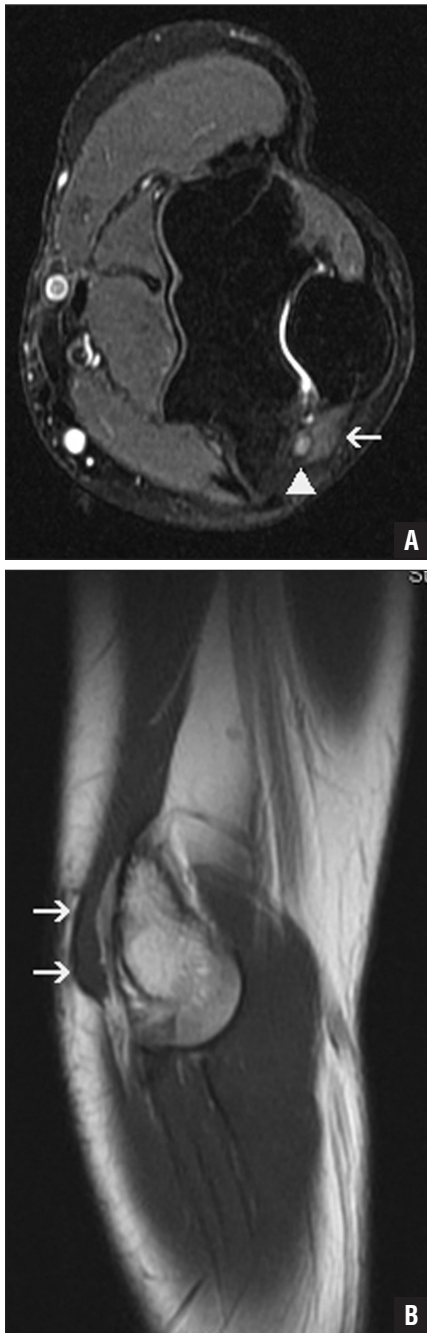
Axial T2-weighted fat-saturated (A) and sagittal T1-weighted (B) magnetic resonance images of the left elbow showing an anconeus epitrochlearis muscle (arrows) compressing the ulnar nerve (arrowhead), with increased signal intensity of the nerve, implying intraneural edema.
